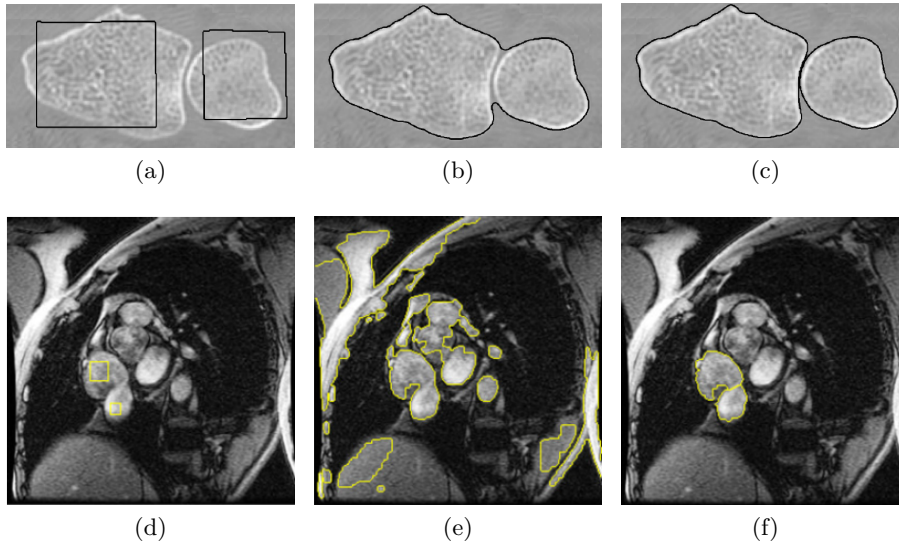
Incorporating topology constraint into medical image segmentation frameworks. Top row: Segmentation of a carpal bones CT image [Han et al., 2003]. Bottom row: Segmentation of cardiac ventricles [Zeng et al., 2008]. (a) Initialization. (b,c) Segmentation without (b) and with (c) topological constraint. (Images adapted from [Han et al., 2003] and [Zeng et al., 2008] by permission)
